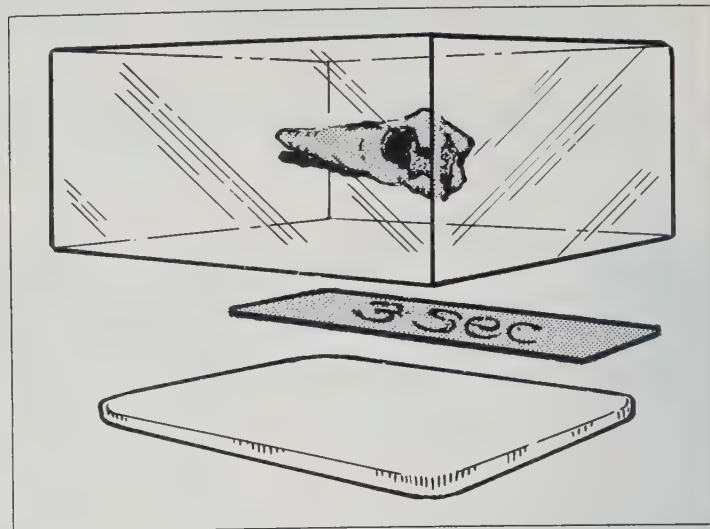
Prior to exposure, the plastic block with the embedded tooth is placed over a film packet on which a lead strip has been placed (the lead backing from a film packet) and on which is written the trial exposure time for that film. The tube of the x-ray machine is positioned 75 mm (3 in) from the film which would equal the distance of the tube to the film when placed in the mouth.
